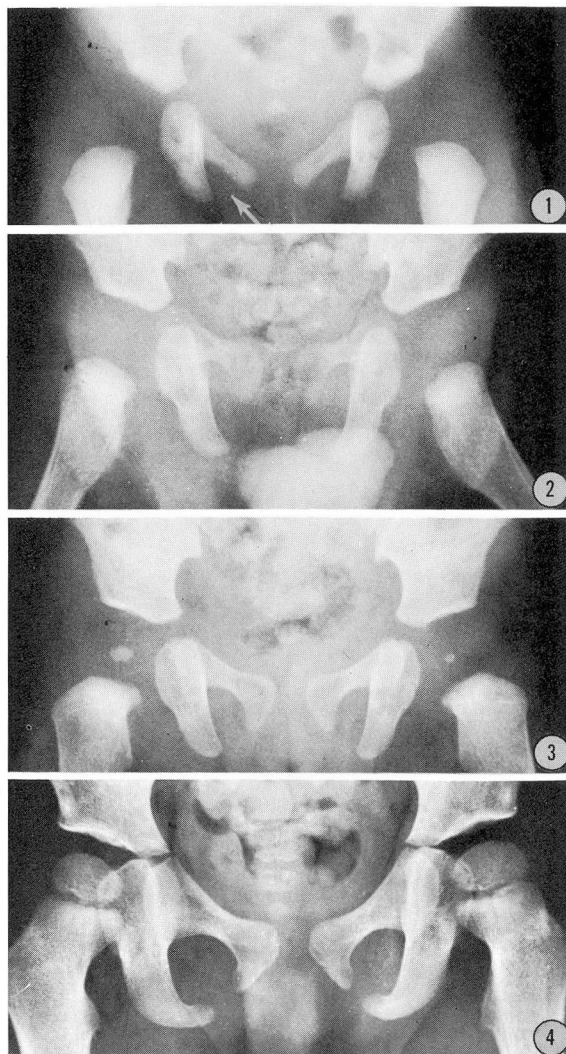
through 16 were among the roentgenograms obtained during the routine examination of 86 children, none of whom had any signs or symptoms referable to Van Neck's disease. The diagnosis at the time of roentgen examination is presented in each legend.
